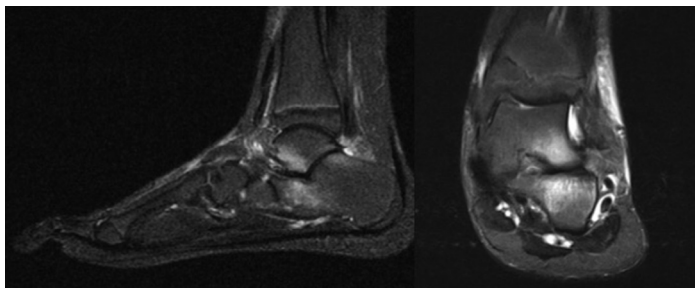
Magnetic resonance image of the foot and ankle showing edema around the subtalar joint, a common finding in patients with painful hindfoot, in both patients with and without a proven tarsal coalition.
